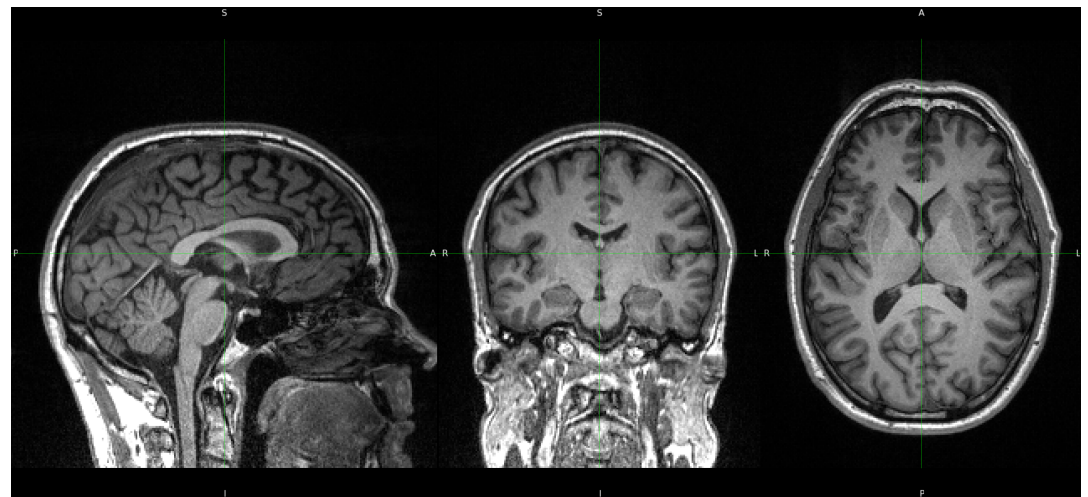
3D T1-weighted MPRAGE recording from BGA_046. Panels left to right: Sagittal, Coronal, and Axial section, respectively. (01-freesurfer-freeview-t1-aseg-bga-046.ipynb)
